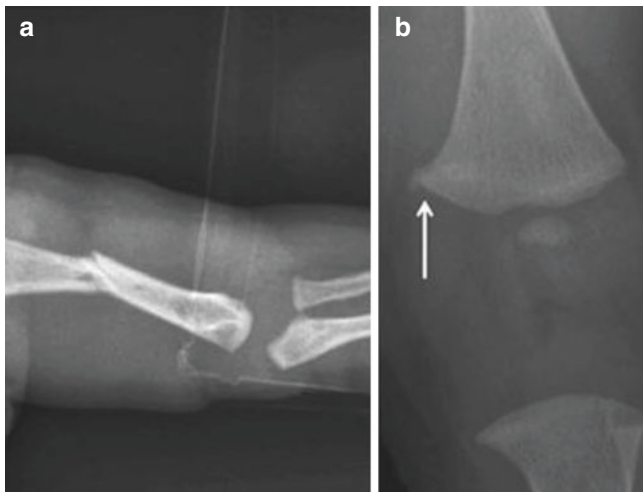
5-month-old boy brought to the emergency department with swelling and deformity of the left arm. (a) Radiograph shows a midshaft humeral fracture. (b) Bone survey showing metaphyseal corner fracture in the left distal femur (*arrow*)
